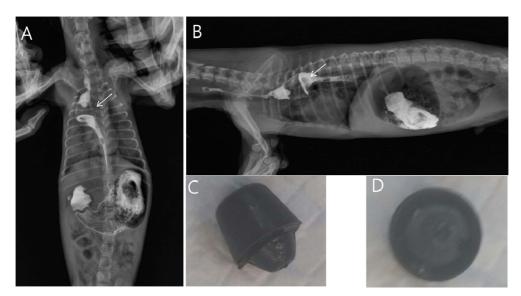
Contrast thoracic radiography of this case. A: Ventrodorsal projection of thoracic radiography revealed a large foreign body (arrow) on thoracic esophagus obstructing trachea. Although the pulmonary infiltration was much cleared out, compared to the beginning of emergency therapy, there was still diffuse infiltration over all lung fields. B: Right lateral projection of thoracic radiography revealed a large foreign body (arrow) on thoracic esophagus obstructing trachea. C & D: The foreign body was removed. It was a 1.8×2.0 cm rubber plug for a climbing stick.
